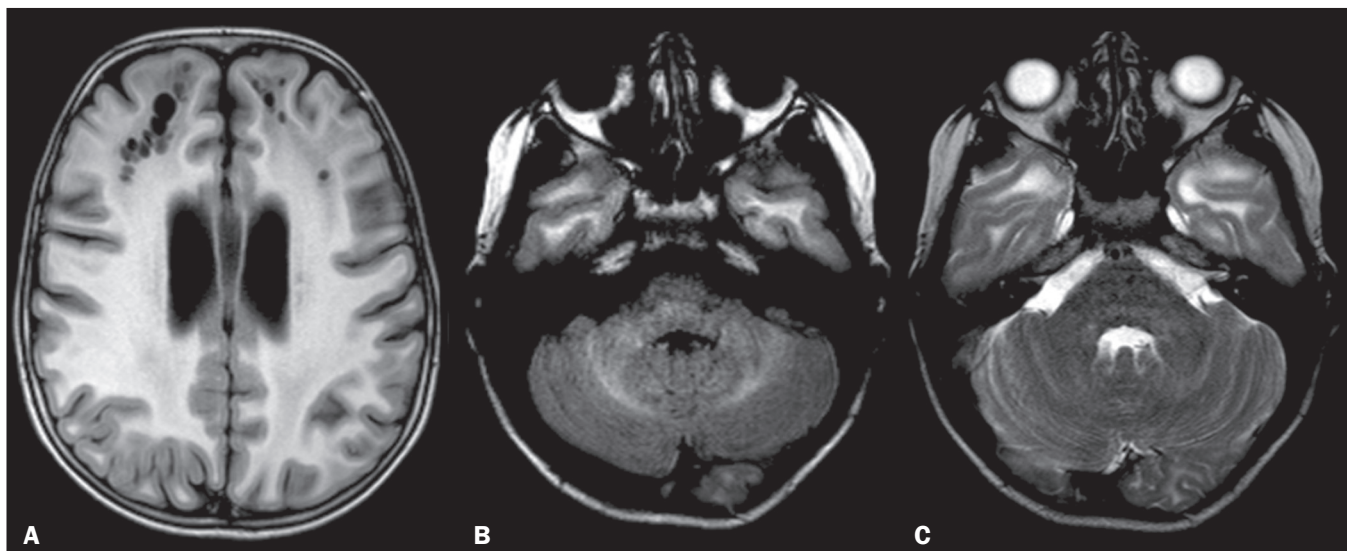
MLC. A: Axial T1WI showing cysts in the white matter frontal lobes and persistence of the cavum septum pellucidum. Axial FLAIR sequence (B) and axial T2WI (C) showing a mildly hyperintense signal in the cerebellar white matter (and in the MCPs), together with diffuse white-matter abnormalities in the temporal and occipital lobes.
